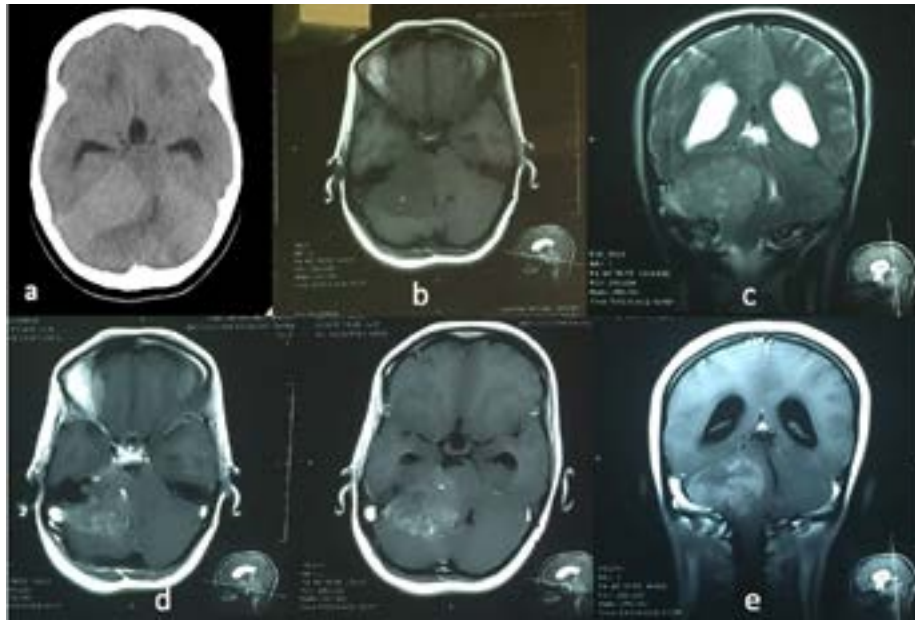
Computed tomography scans
